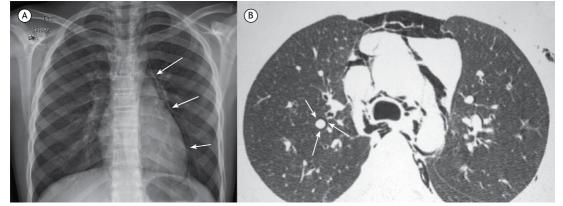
In A, chest X-ray showing a linear opacity parallel to the left mediastinal border, representing the laterally displaced mediastinal pleura separated from the mediastinum by a band of air (arrows). In B, HRCT scan of the chest showing the presence of free gas in the mediastinum, dissecting into anatomical structures (bronchi and vessels). Also note the presence of gas surrounding a pulmonary vessel on the right (arrows).
